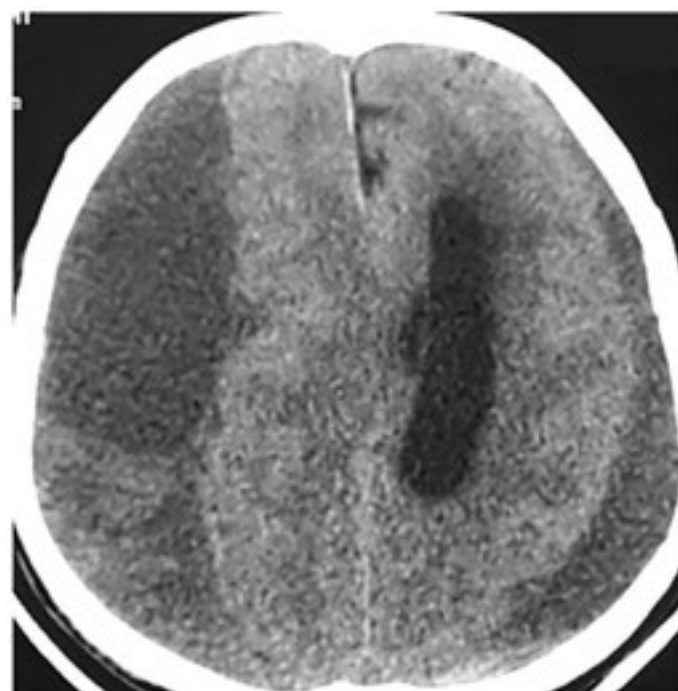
CT brain scan showing bilateral chronic subdural hematoma. The right side was larger and there was a midline shift and absent right ventricle.
